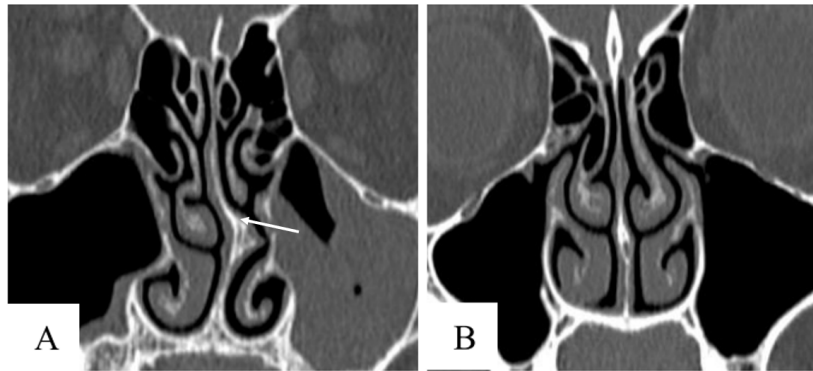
CT-scan of a septal deviation patient (A) and a healthy person (B), adapted from Mohapatra et al. (2017). In a CT scan, the black region is the airway, the gray region is the soft structures, and the white area is the bone structures. A brief introduction regarding CT scans can be found in section 3.1.2. In figure (A), the nasal septum (labeled with a white arrow) deviates to the left, causing the airway in the middle-inferior meatus to change. In comparison with the pathological case, the healthy nasal septum in figure (B) is almost straight.
